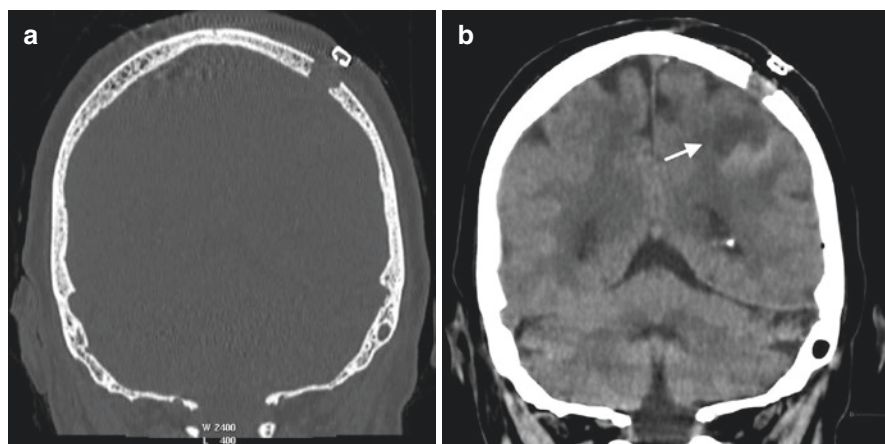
Burr hole complication with venous stroke in a 45-year-old woman, 2 weeks after stereotactic biopsy of a brain tumor. Coronal CT scan (a, b) obtained with a bone algorithm (a) shows frontal burr hole. Parenchyma hypoattenuation (b) adjacent to the frontal burr hole, represent a venous stroke (arrow)
